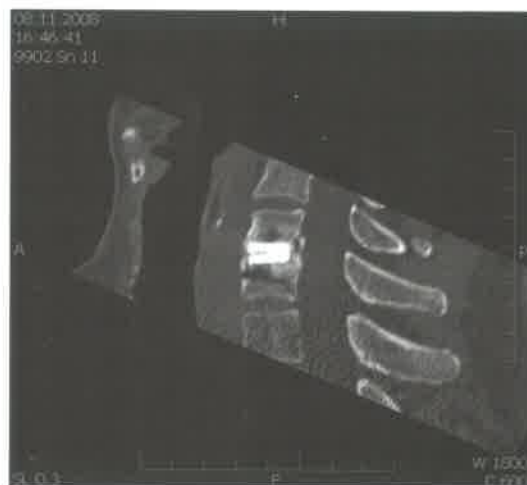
CT after 6 months Implaspin C6/7 sagittal cut.
